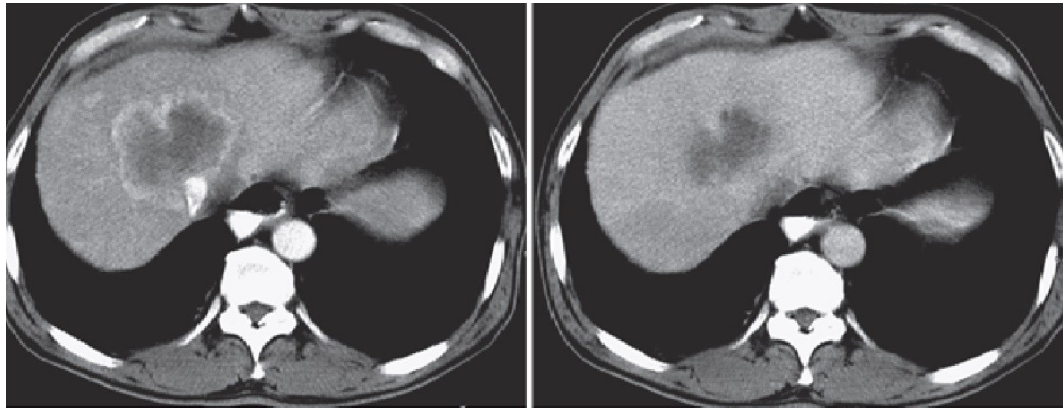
CT image showing peripheral cholangiocarcinoma
